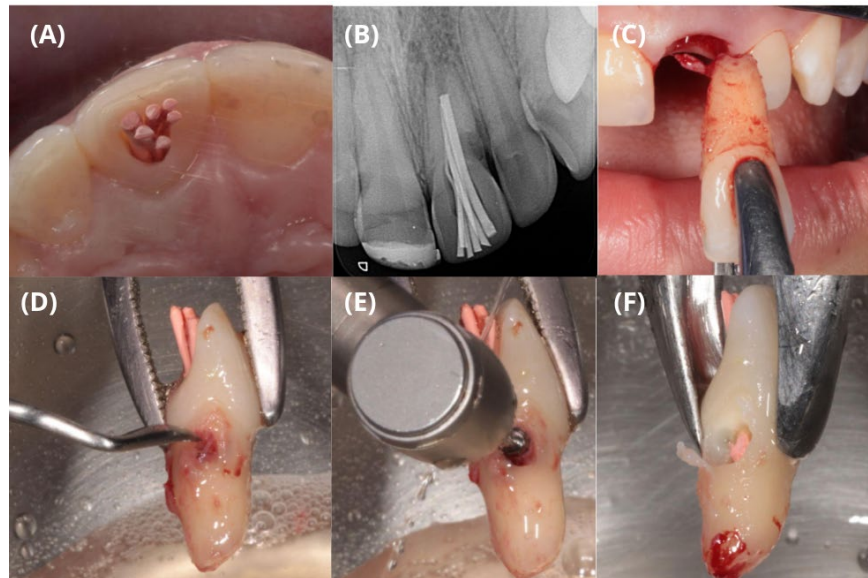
A) Clinical appearance of the root canal filled with gutta-percha cones; B) Radiographic appearance of the root canal filling with accessory gutta-percha cones; C) Atraumatic extraction of tooth #21; D) Removal of granomatous tissue with a curette; E) Removal of resorptive tissue with an FG #5 carbide bur; F) Appearance of the root after removal of the granomatous tissue
